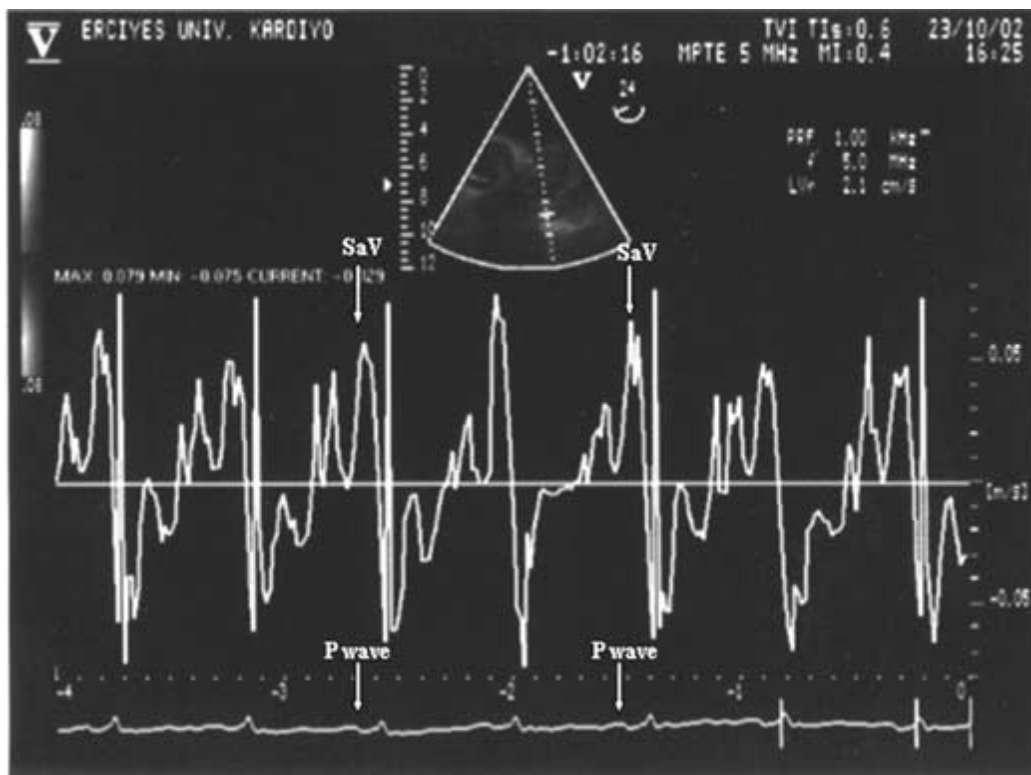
The velocity profile at the tip of left atrial appendage extracted from the color Doppler tissue imaging (black and white print). SaV: systolic appendage velocity.
